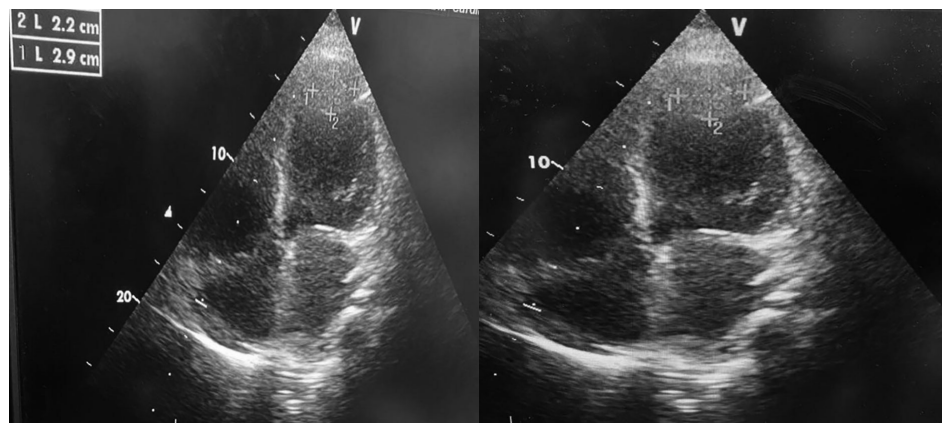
The echocardiogram revealed an uncertain apical thrombus measuring 22 by 29 millimeters in the apical four-chamber view
